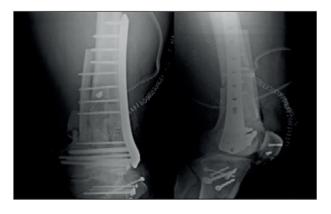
Postoperative radiographs following surgery 7 days after injury
